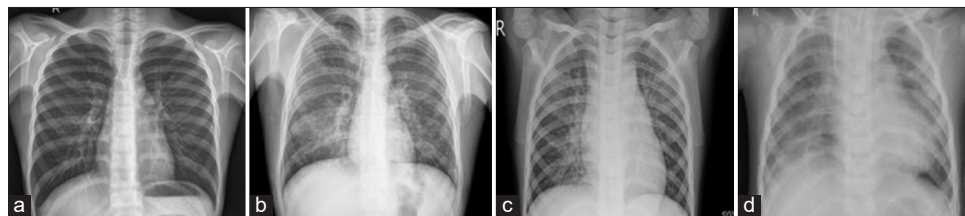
A representative sample of downloaded lung chest X-ray images from Github repository: Healthy asymptomatic normal (in a), diagnosed COVID-19 infected (in b), diagnosed viral pneumonia (in c), and diagnosed bacterial pneumonia (in d)
